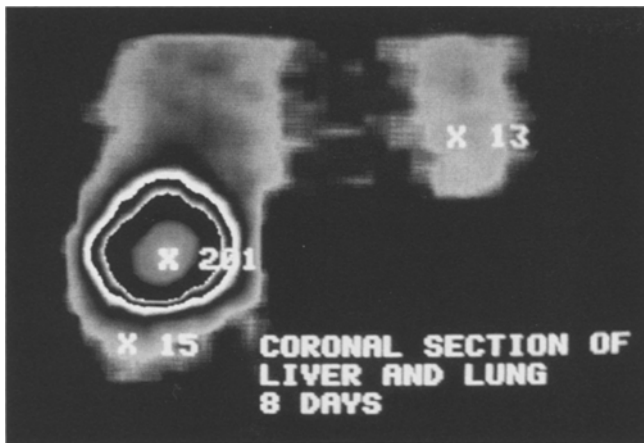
Single-photon emission computed tomography (SPECT) discloses high tumor-to-normal liver and lung ratios on the same pixel counts.
